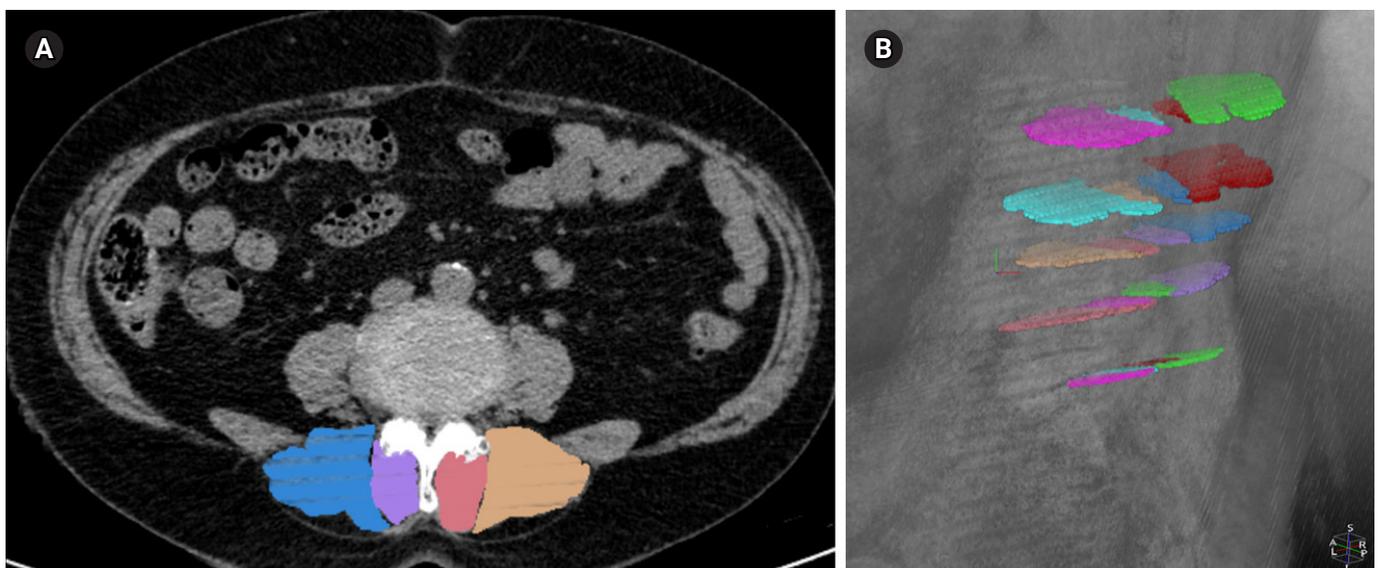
Measurements of cross-sectional area and density of lumbar paraspinal muscle. (A) Computed tomography axial image at the L3/4 disc level and (B) three-dimensional reconstructed bird's-eye view from the top-left of the participant.
